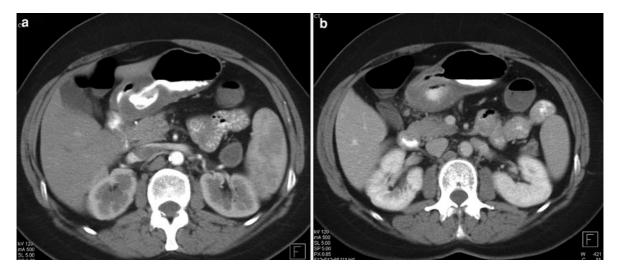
54-year-old woman with large ulcer in the gastric antrum. Axial images from arterial phase (a) and venous phase (b) IV contrast-enhanced CT show wall thickening with a large ulcer crater involving the posterior wall of the antrum.
